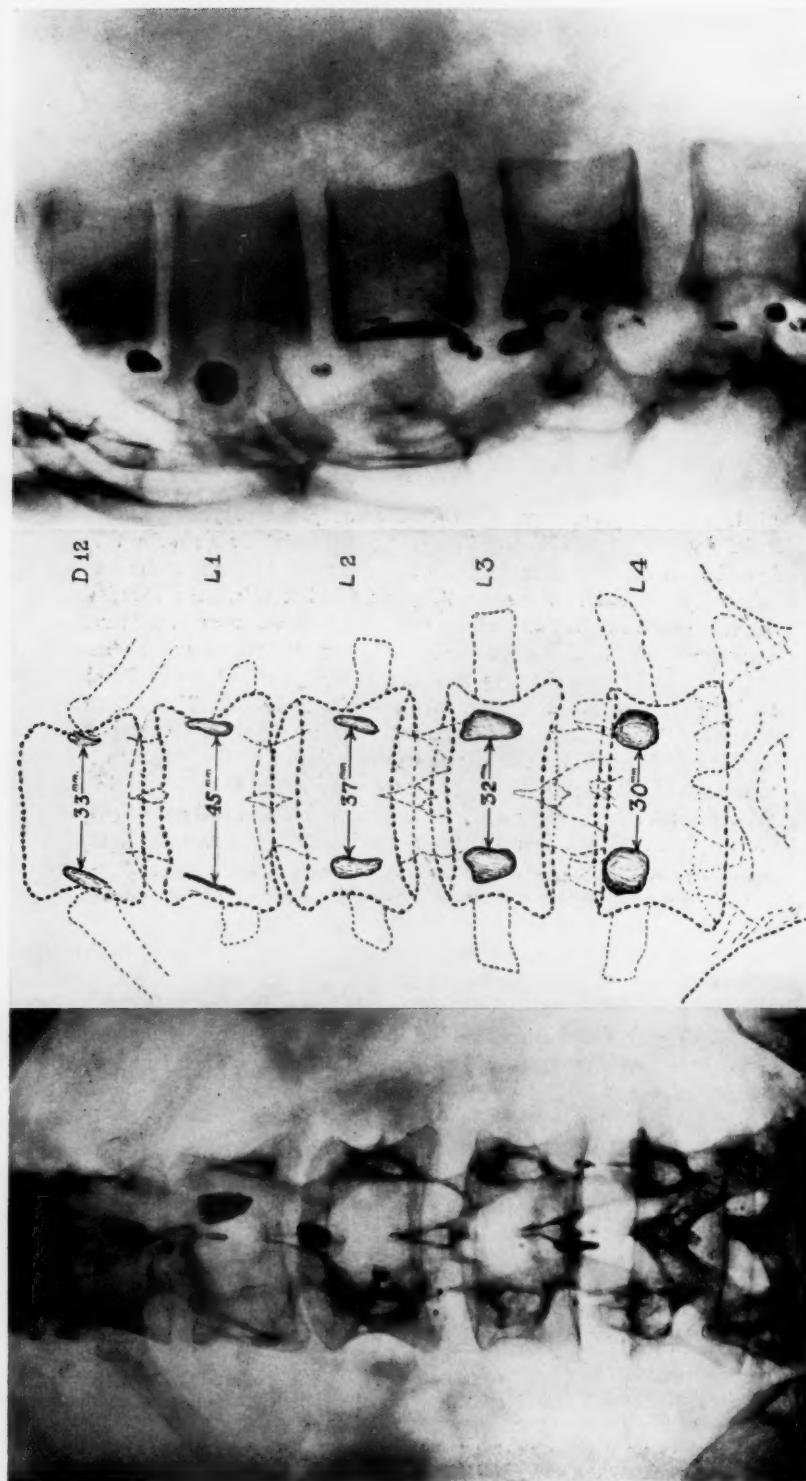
Roentgenogram showing enlargement of the spinal canal with atrophy of the pedicles of the twelfth thoracic and first, second and third lumbar vertebrae. Lipiodol seen above and below the lesion demonstrates the absence of a block in the cerebrospinal fluid.
